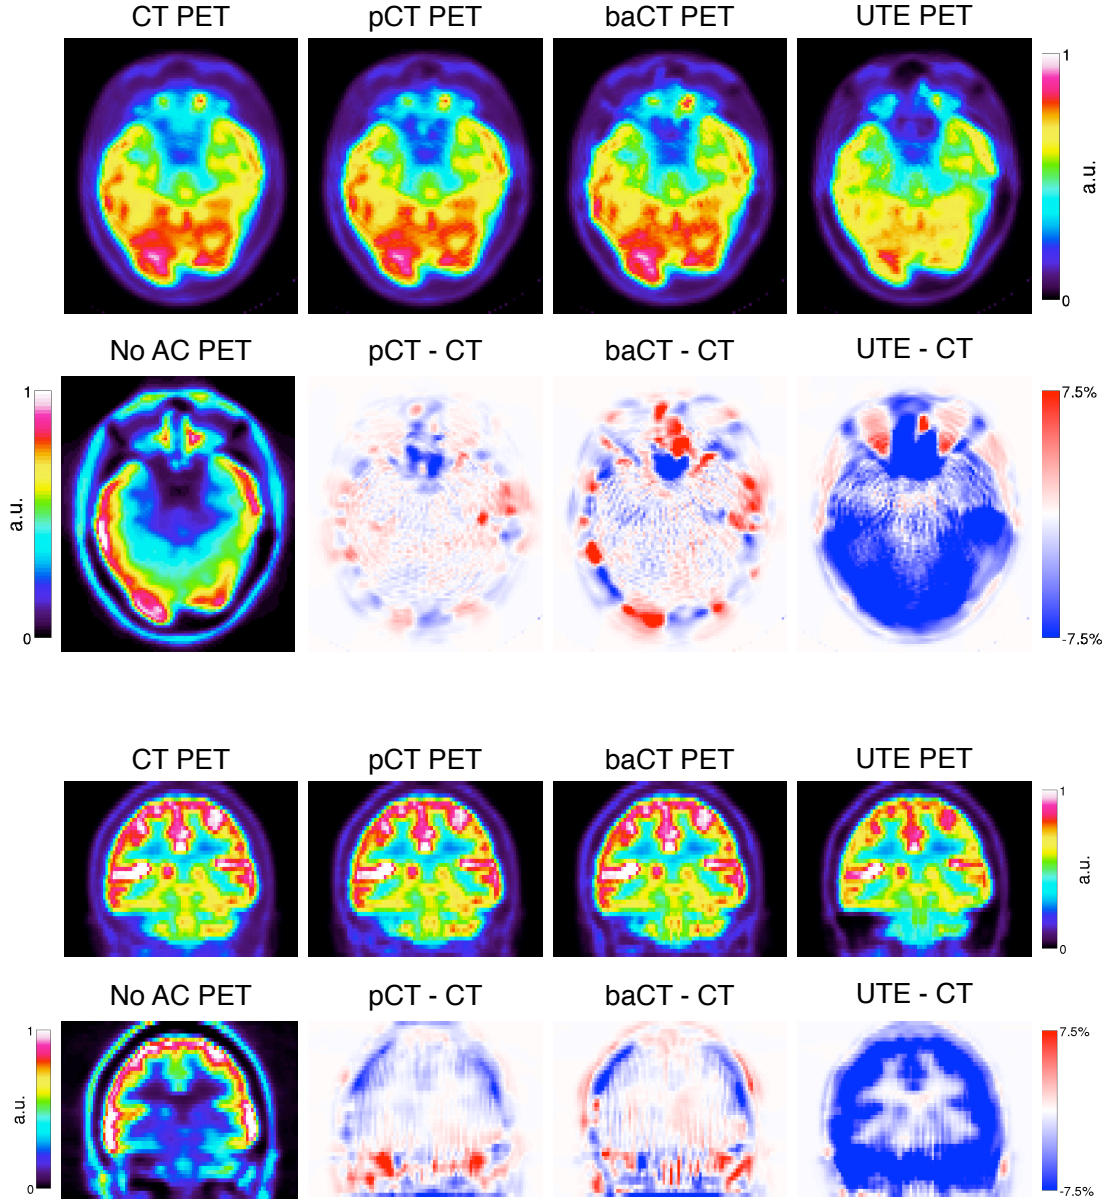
For subject 1, from left to right: The reference FDG PET, the pCT PET, the baCT PET and the UTE PET (top); the non corrected PET, the difference between the pCT and CT PETs, the difference between the baCT and CT PETs, and the difference between the UTE and CT PETs (bottom).
